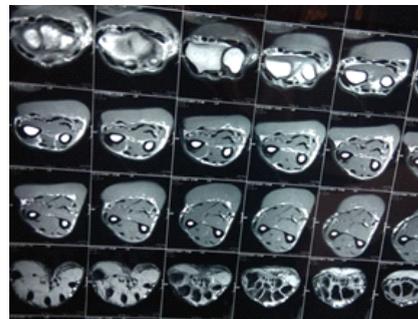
Cut Sections of MRI showing a better understanding of the tissue planes.
